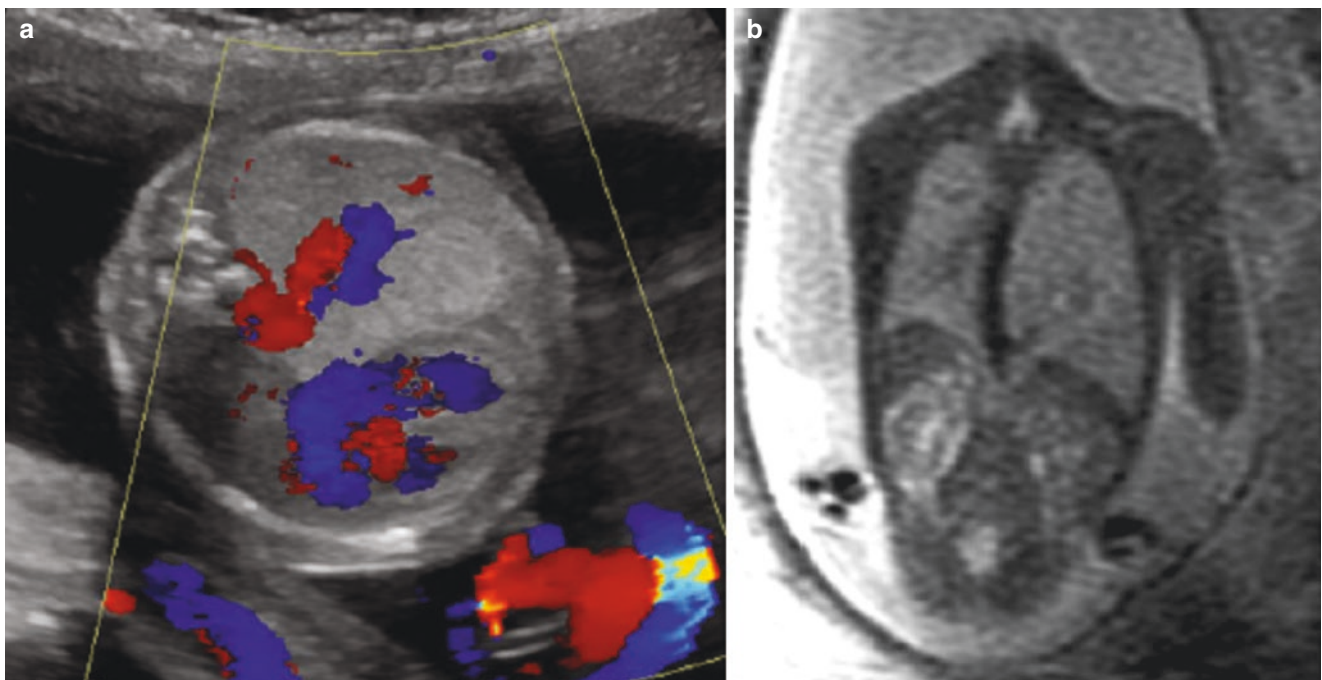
Bronchopulmonary sequestration. (a) Axial US image of the fetal chest with power Doppler documents an echogenic mass in the left lung with systemic vessels coursing into the mass. (b) Coronal SSFSE
